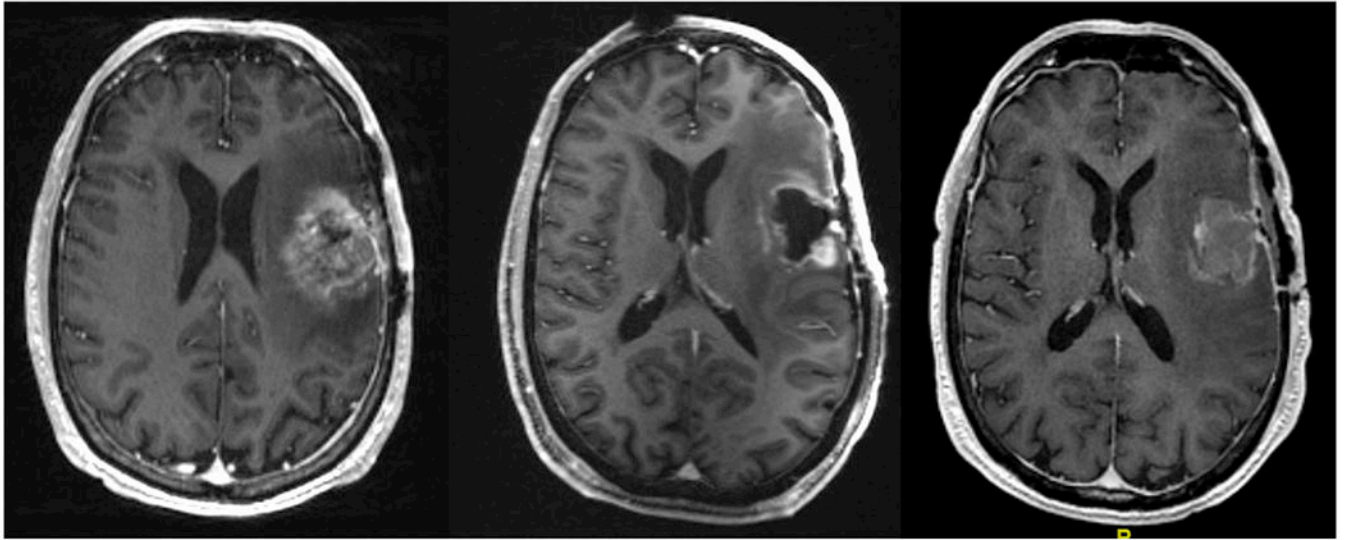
Preoperative contrast-enhanced T1-weighted MRI of a recurrent GBM (*left*), intraoperative contrast-enhanced T1-weighted MRI showing residual tumor under the lip of the resection edge (*middle*), postoperative T1-weighted contrasted MRI showing gross total resection of enhancing tumor (*right*).
